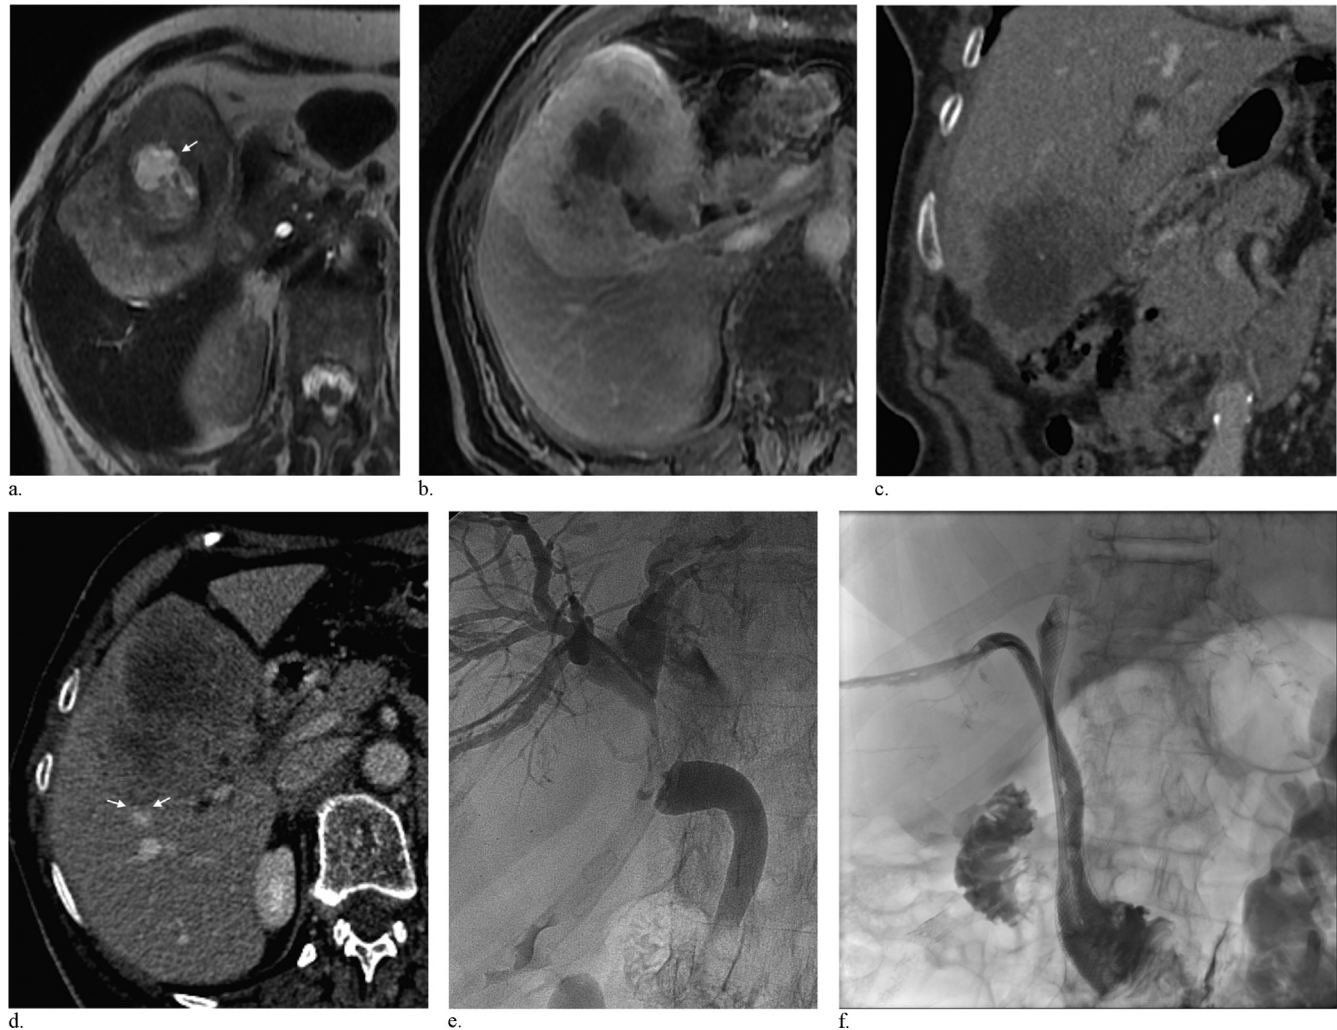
Images from a 71-year-old woman referred with jaundice and colic pain. (a) T2-weighted axial MR image shows the mass arising from the thickened gallbladder wall (arrow), invading segments IV/V. (b) Delayed fat-saturated T1-weighted postcontrast image shows retention of gadobenate dimeglumine within the tumor. (c) Coronal CT view demonstrates a hepatic lesion that infiltrates the right colic flexure. (d) Axial CT image in portal-venous phase shows infiltration of the right PV branch (arrows). The tumor was classified as stage IVA (T4N0M0). (e) PTC shows tight sub hilar stricture of the CBD. (f) Bilateral self-expandable metal stents were inserted percutaneously to allow bilirubin normalization and chemotherapy administration.
